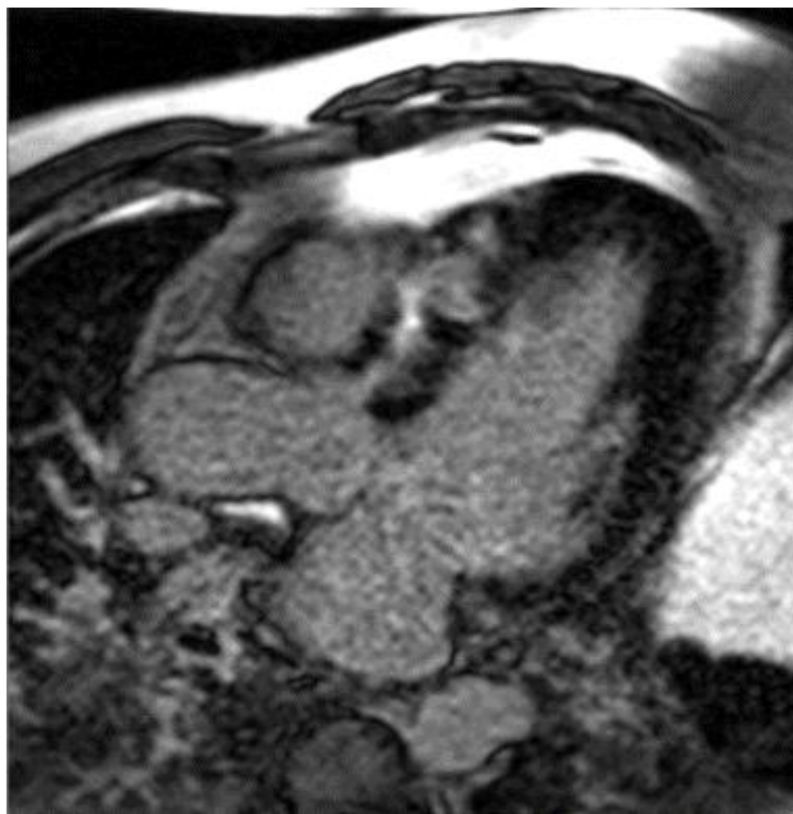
Late gadolinium enhancement (LGE) image from a cardiac magnetic resonance image in the three-chamber view showing significant fibrosis in the anteroseptum of a patient with hypertrophic cardiomyopathy. Image courtesy Arlene Sirajuddin, MD.
